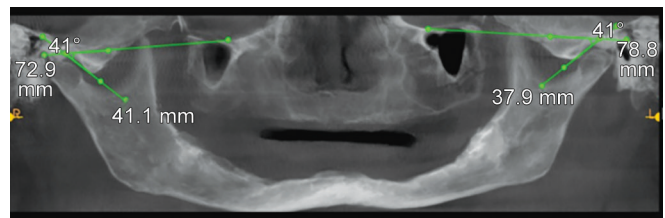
HCI measurement – CBCT using CS 3D imaging software, Carestream Dental
